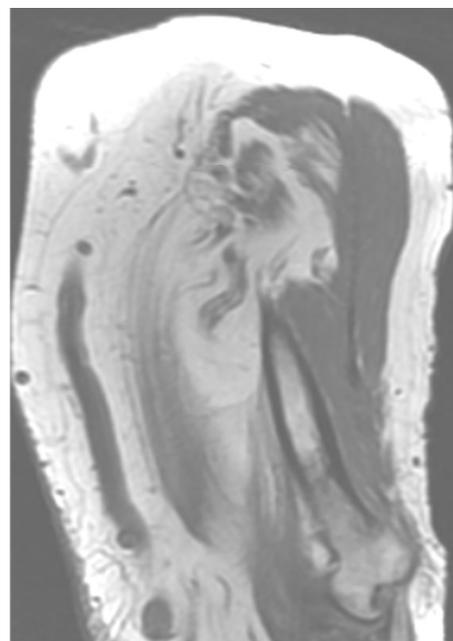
MRI T1 weighted sagittal view. The radial nerve appears like “cables”. In T1 sequences, fatty tumour tissue is hyperintense and the fascicles, hypointense.
